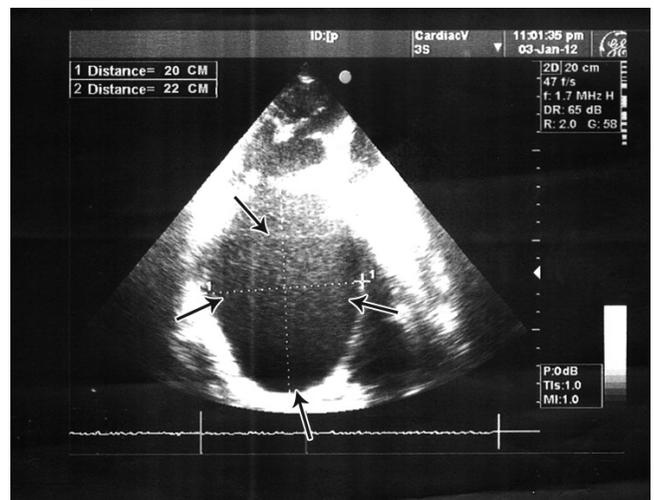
Echocardiography in the four-chamber view, showing a gigantic left atrium (arrows)
